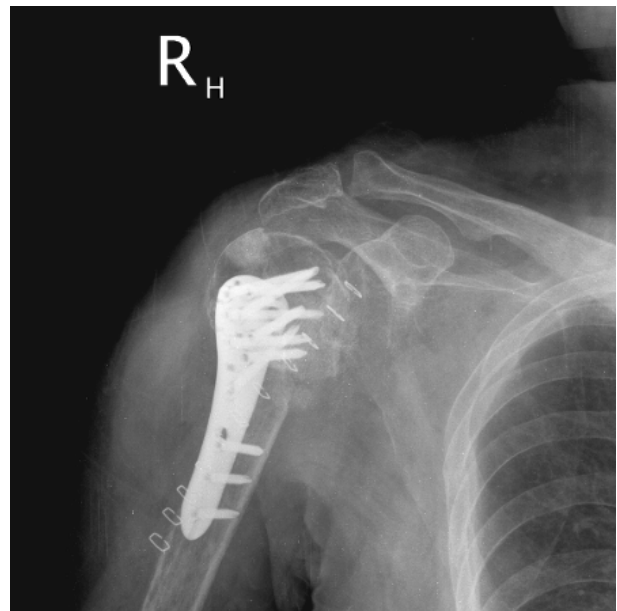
Immediate post-operative radiograph confirmed satisfactory implant and allograft position with good overall alignment.
